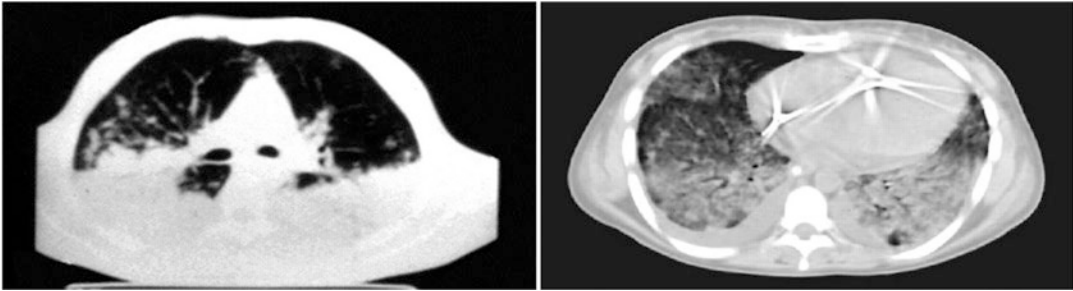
The computed tomography of the lungs showing ground-glass opacities (especially in the posterior gravity-dependent portions) with some normal lung tissue
